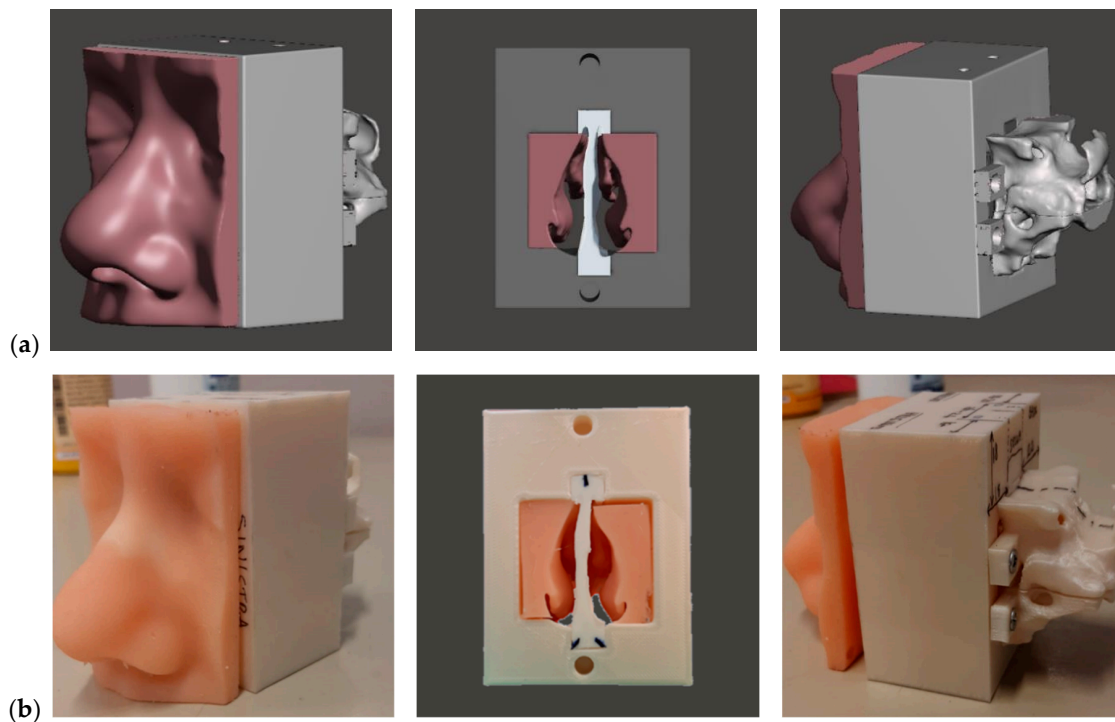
The CT-based anatomical training model. CAD (a) and assembled model (b).
